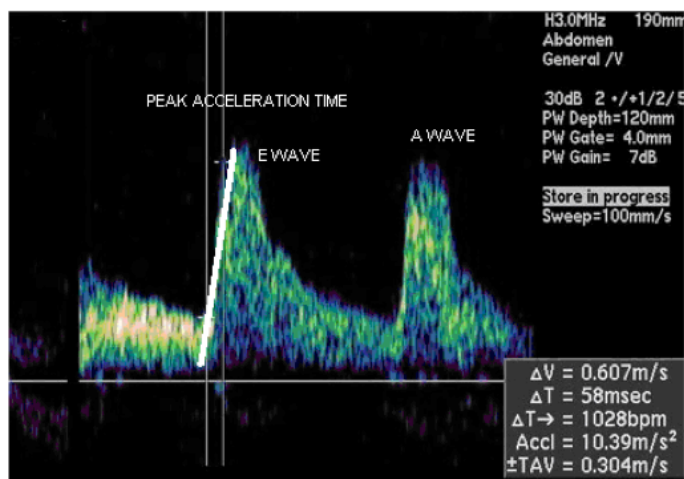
Measurement of pkAcc on Mitral E wave by PW-Doppler
